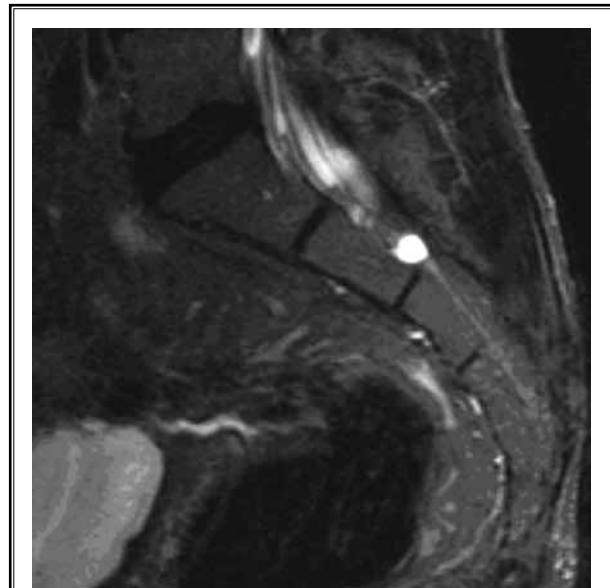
Sagittal T2 MRI demonstrating hyperintense TC at the S2/3 junction with mild sacral laminar erosion.
